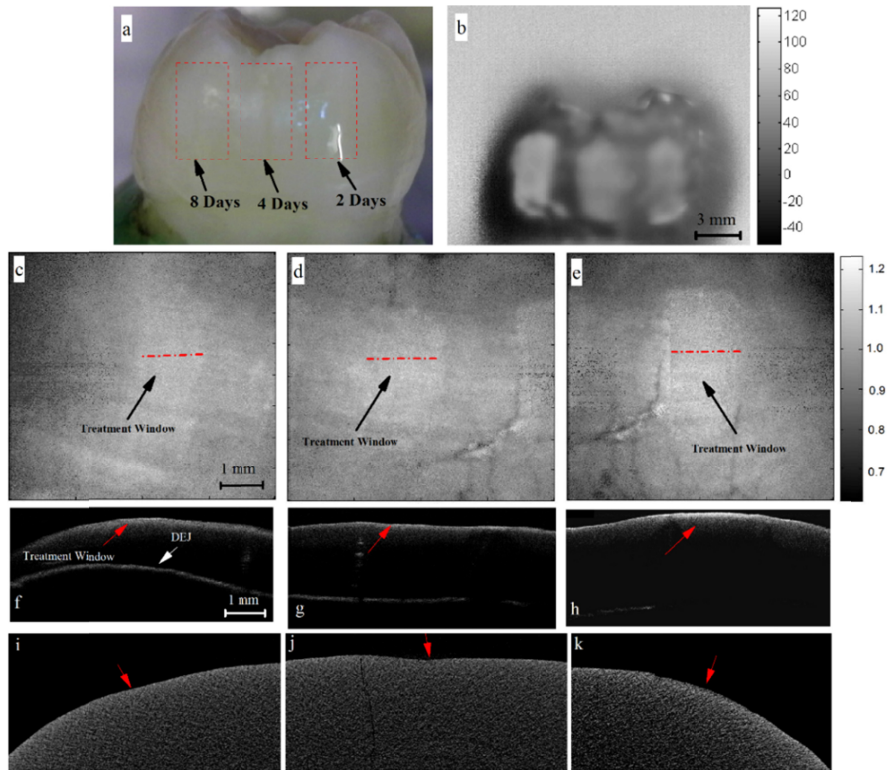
(a) Visual image of tooth with artificially-induced caries at 3 locations. (b) TPLI phase image at 2-Hz modulation frequency. Integrated *en-face* OCT images at (c) 2 days, (d) 4 days, and (e) 8 days of demineralization. B-scan OCT images at (f) 2 days, (g) 4 days, and (h) 8 days of demineralization.  $\mu$ CT images at (i) 2 days, (j) 4 days, and (k) 8 days of demineralization.
